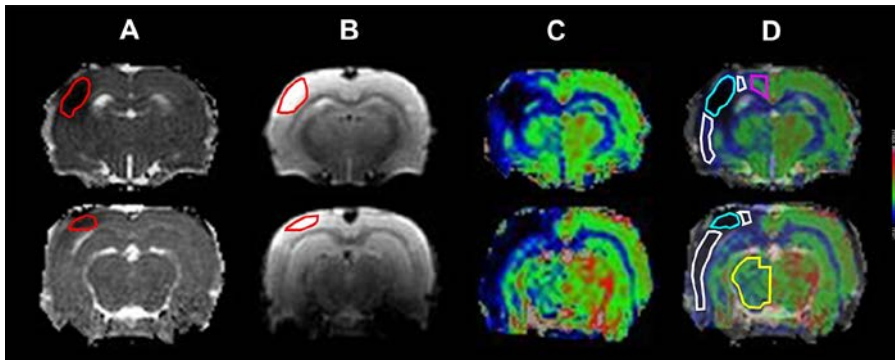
Regions of interest (ROIs) used in paper II. (A) Ischemic core regions (red) seen in apparent diffusion coefficient maps (A) and T2-weighted images (B) (C) Cerebral blood flow (CBF) maps. (D) CBF maps overlain with ADC maps. ROIs used to examine the CBF of the Ischemic Core (cyan), penumbra (white), anterior cerebral artery supply regions (purple), and posterior cerebral artery supply region (yellow).
